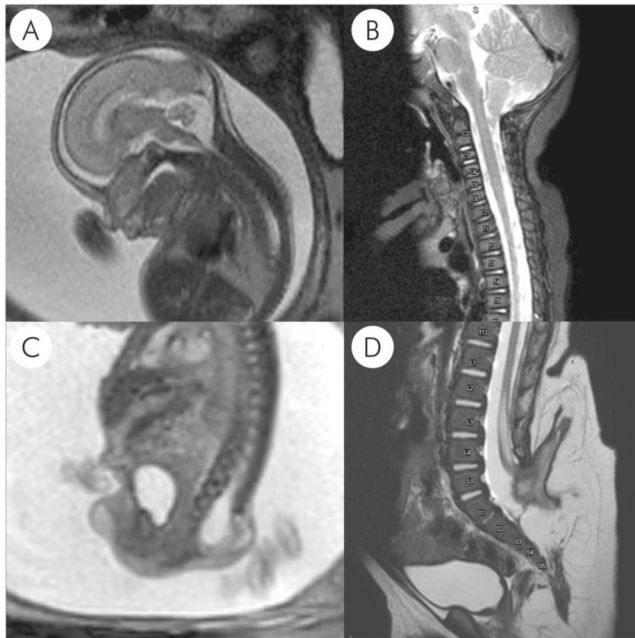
(A–D) Pre- and postnatal MRI images of case 3 at 24 weeks GA and after birth (case 3): (A) Sagittal T2-weighted fetal MRI reveals a normal sized posterior fossa, with a well-defined, non-compressed fourth ventricle and a mega cisterna magna; (B) Postnatal sagittal T2-weighted MRI shows a downward displacement of cerebellar tonsils into the upper cervical spinal canal, the fourth ventricle is patent. (C + D) Fetal (24 weeks GA) and postnatal T2-weighted sagittal MRI image of the spine show a large and complex lumbo-sacral malformation with imaging features compatible with a myelocystocele (case 3).
